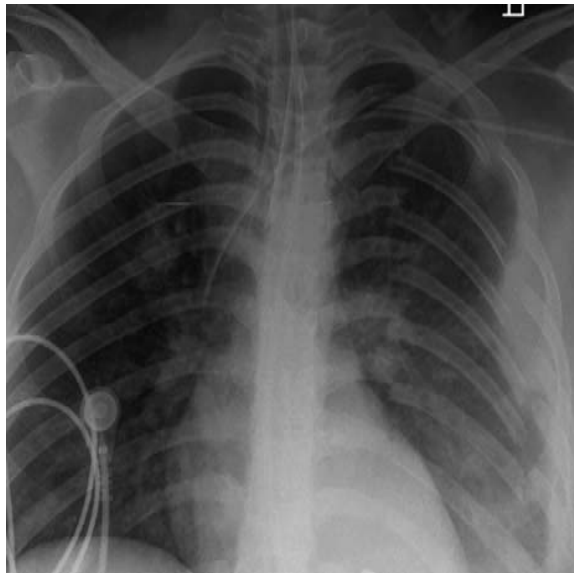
Frontal chest radiograph shows fractures at two locations in the left posterior third through to the eighth ribs. Patient required treatment for a flail chest. (Miller, 2008)
